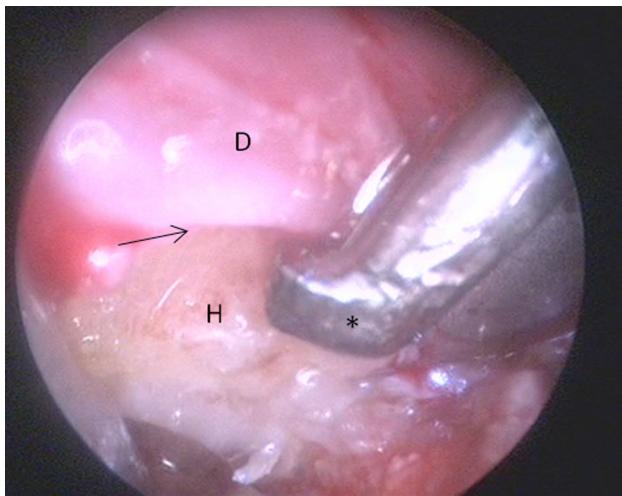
Intraoperative endoscopic view (Case 2 of this paper). The interface (arrow) between the ventral dura (D) and the calcified herniation (H) is under control. An ultrasonic bone curette (asterisk) is used to resect the herniation while leaving the dural sac untouched
